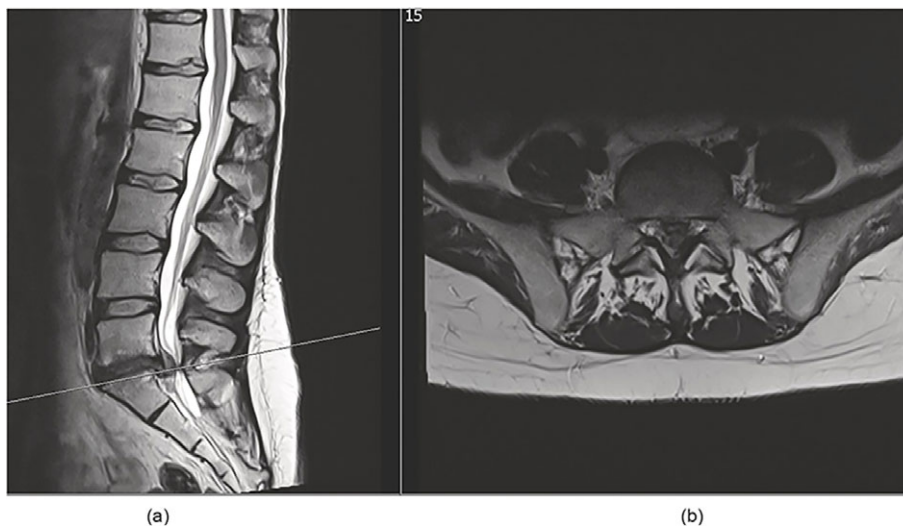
(a) Sagittal T2 and (b) axial T2 at level of interest MRI scan spine
